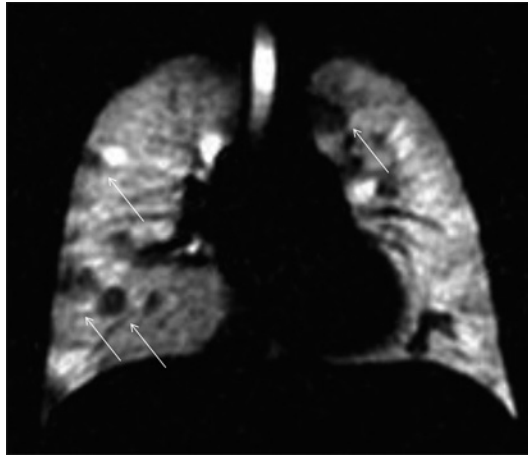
He³ MRI. Hyperpolarized helium (He^3) ventilation image from a cystic fibrosis (CF) child with normal spirometry and normal looking computed tomography (CT). Note areas of inhomogeneous ventilation (white arrows). Courtesy of Jim Wild, University of Sheffield.
